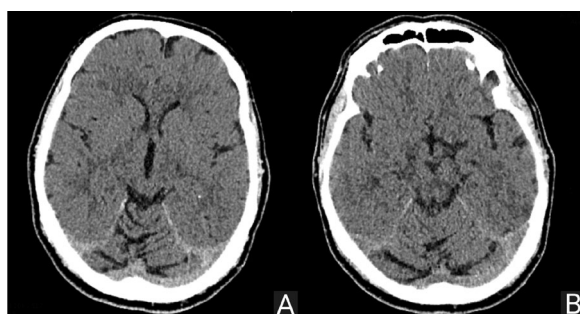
Computed tomography scan of the head of patient 1 on admission (A) and control after several days (B). Brain and cerebellum without focal changes; no signs of intracranial bleeding
